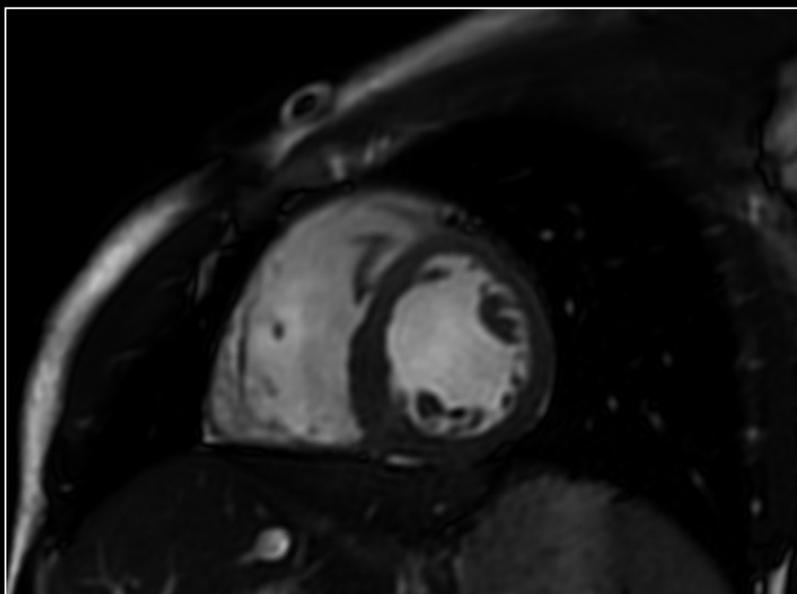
Short axis 2D FIESTA. The combination of SIGNA™ Premier and AIR™ delivers high SNR and high image quality for excellent cardiac MR imaging results at 3.0T.
